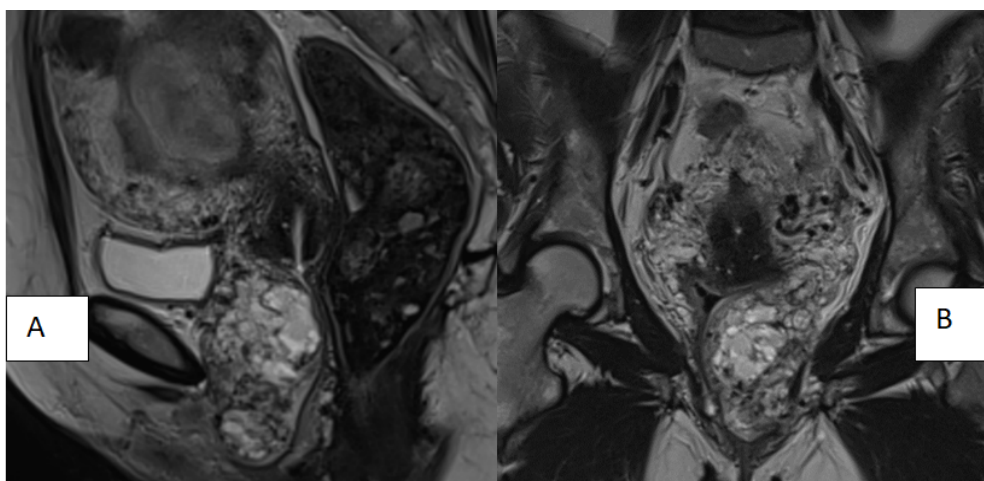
Sagittal T2-weighted (A) and coronal T2-weighted (B) images showing a poorly defined, irregularly contoured, circumferential lesion occupying the entire uterine cavity, predominantly tissue-like, with high T2 signal intensity.
